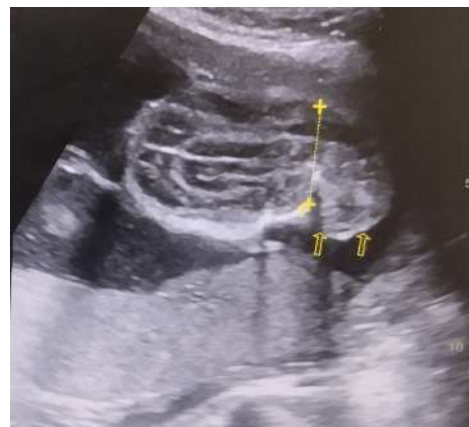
Posterior encephalocele. Sagittal prenatal ultrasonographic image obtained at 26 weeks' gestation demonstrating a posterior calvarial defect with extracranial herniation of intracranial contents (yellow arrows), consistent with a posterior encephalocele.
